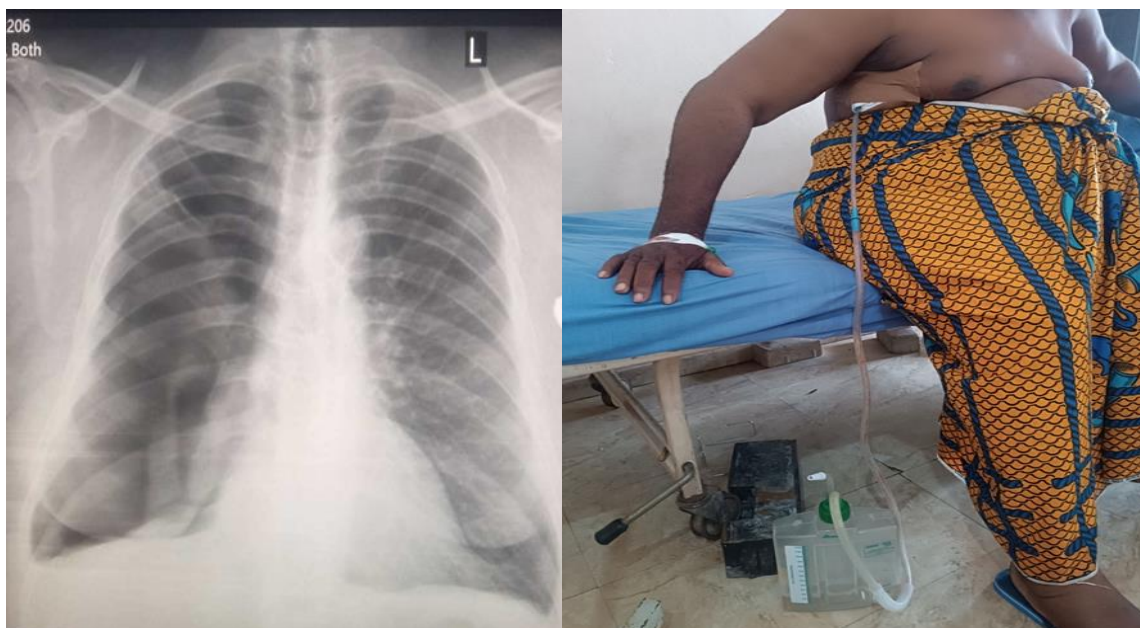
Initial chest x-ray showing pneumothorax and the patient after 2nd chest tube insertion
